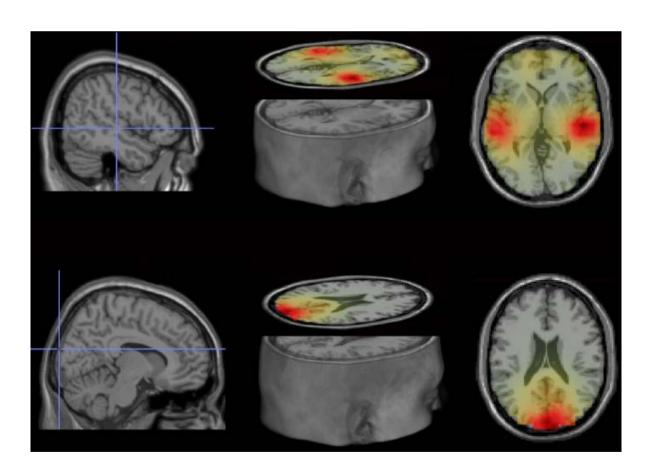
Source localisation of theta power in the unimodal conditions. Top: Auditory sources, MNI coordinates of ROIs: right, 50, -21, 0; left, -60, -29, 0. Bottom: Visual source, MNI coordinates of ROI: 10, -99, 20. Evoked power was averaged over 3.5 and 4.5 Hz, between 0.75 and 2.75 s at each virtual electrode in the unimodal movie and sound conditions and the baseline conditions (see Materials and Methods). Grand average power differences between unimodal conditions and baseline conditions were interpolated to a MNI MRI template. The source coordinates were determined by where the maximum grand average power differences were.
